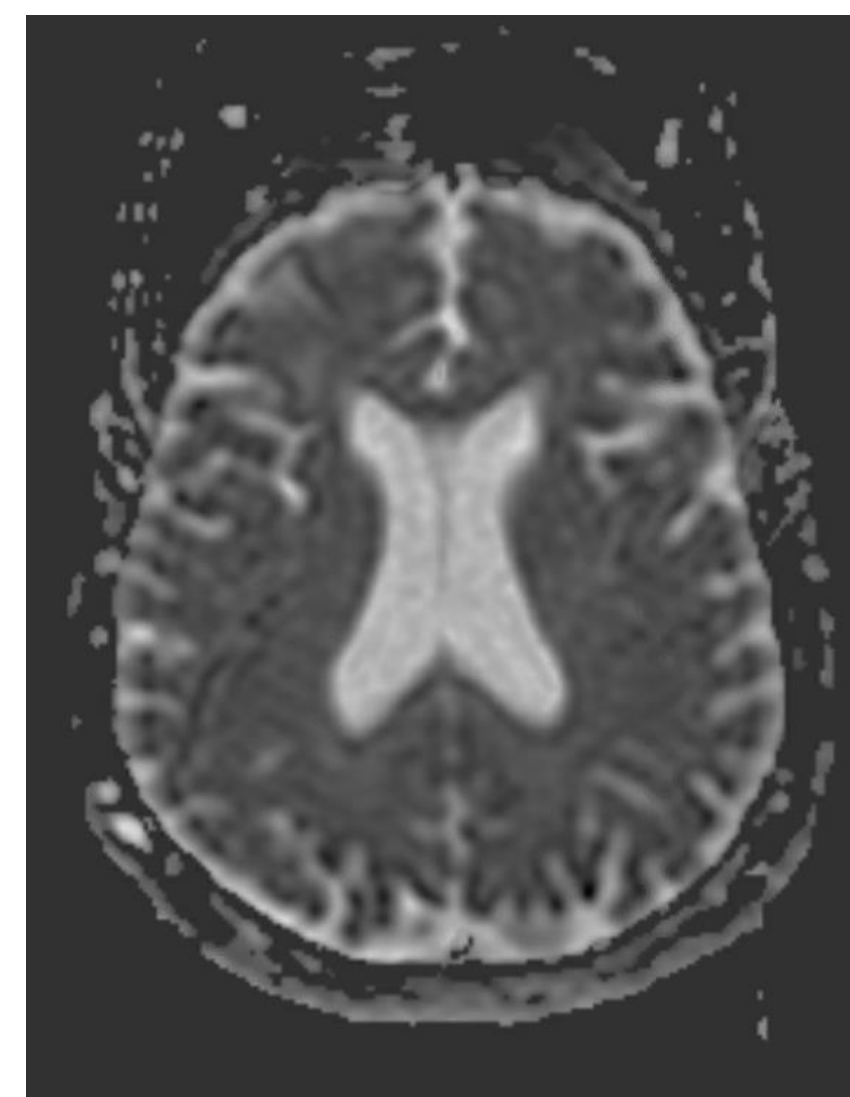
MRI on Day 5 showing chronic vascular ischemic changes but no other abnormalities.
